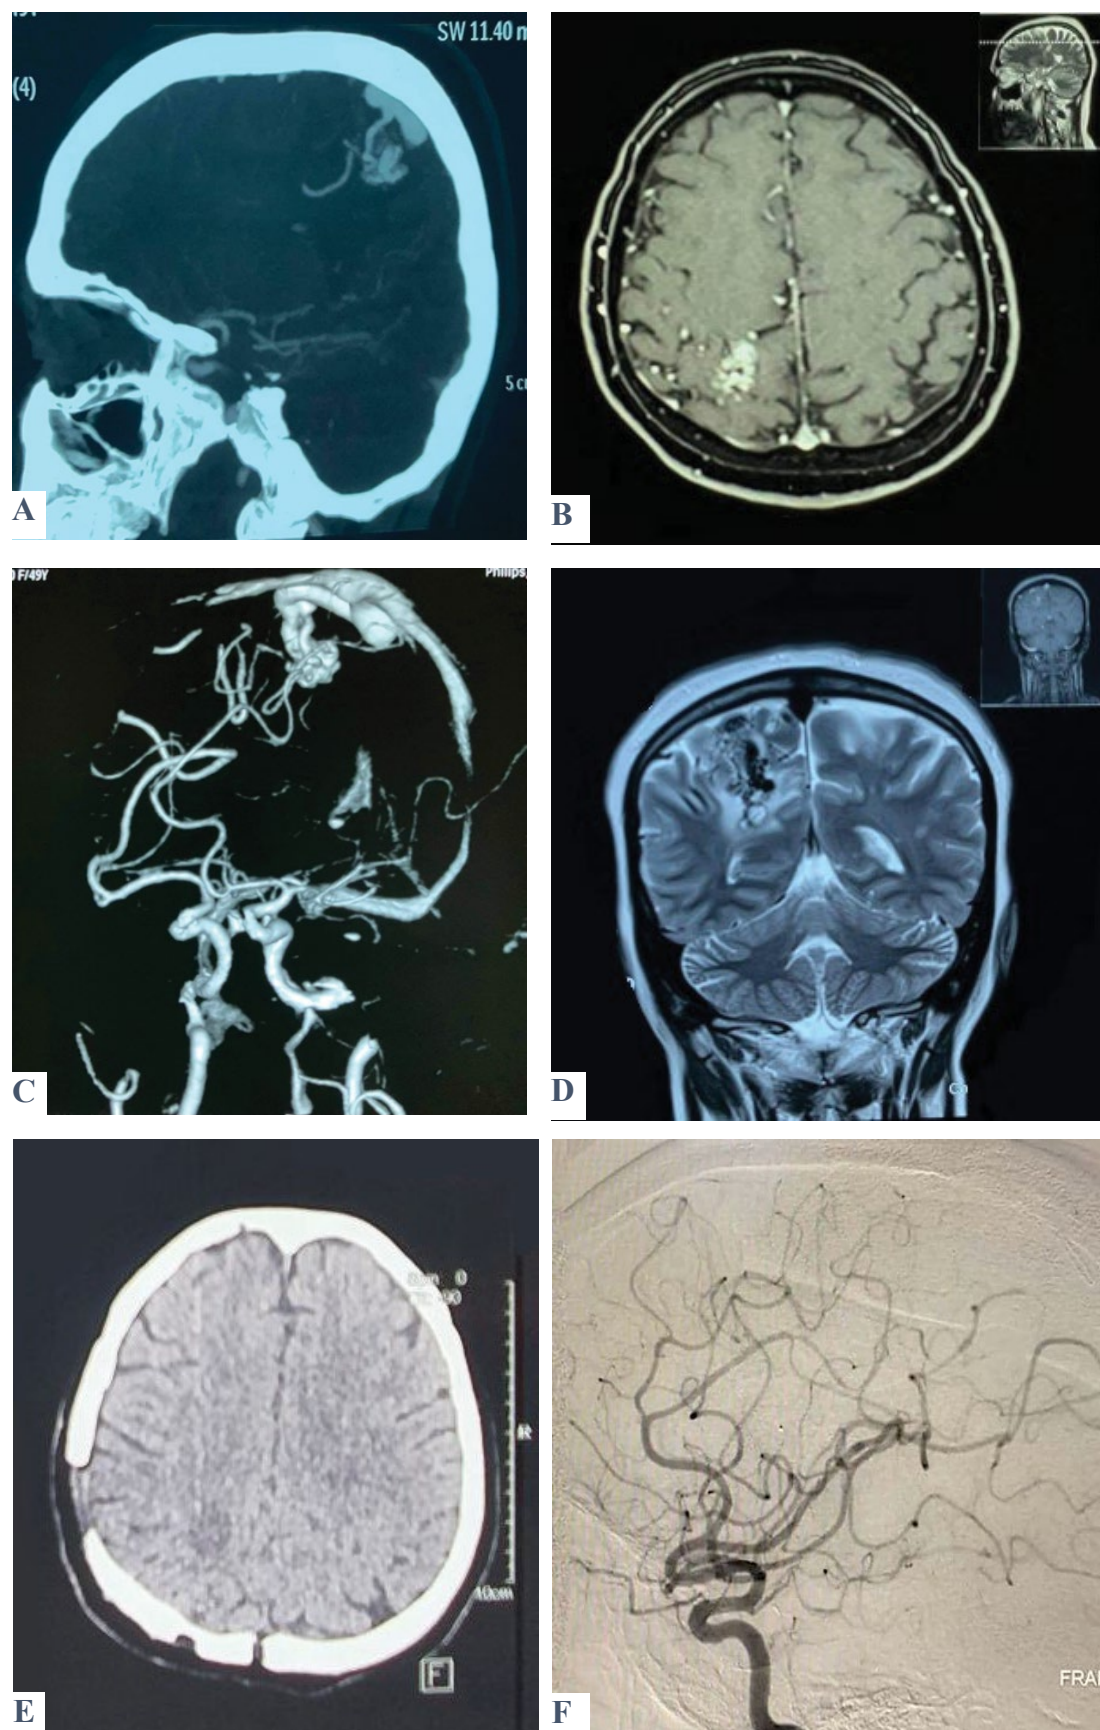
Shows a case of a 49-year-old female patient presented with three attacks of seizures. On admission, GCS was 15, with no fit, no vomiting, and no motor or sensory deficit. A brain CT scan (A) and MRI (B) show a heterogenous lesion within the posterior part of the Rt. parietal lobe involving the sensory area consistent with AVM, which was confirmed by MRA (C) and MRV (D). Post-operatively, GCS was 15 with no fit or vomiting. There was left-lower limb weakness but relieved on successive days. A postoperative brain CT scan and DSA revealed total excision of the lesion (E & F).
